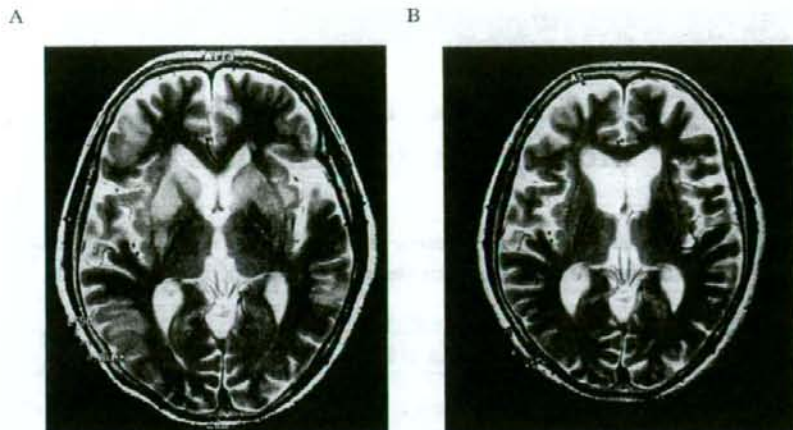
MRI findings on T2-weighted image of this patient. A: There were wide high intensity lesions at bilateral basal ganglia on the 19th day of the first hospitalization. B: There was no intracranial abnormal lesion including basal ganglia on the 20th day of the second hospitalization.
